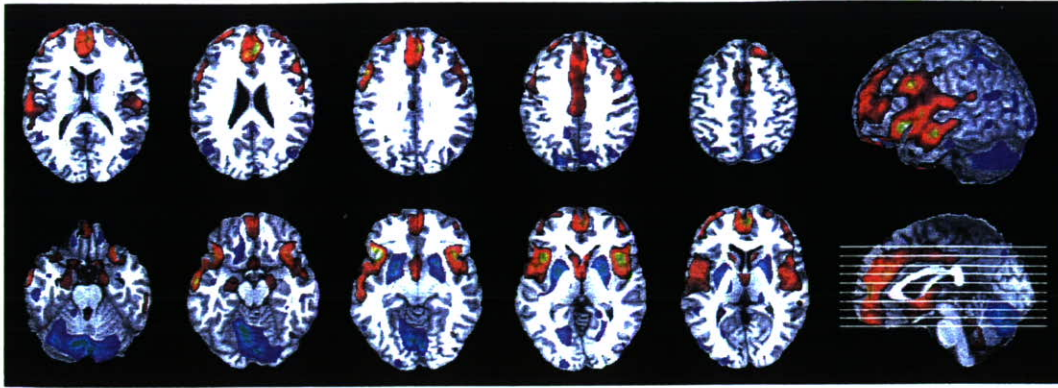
Eigenimage superimposed on a representative MRI image with the 30% largest loadings for positive (in red) and negative (in blue) loadings.
